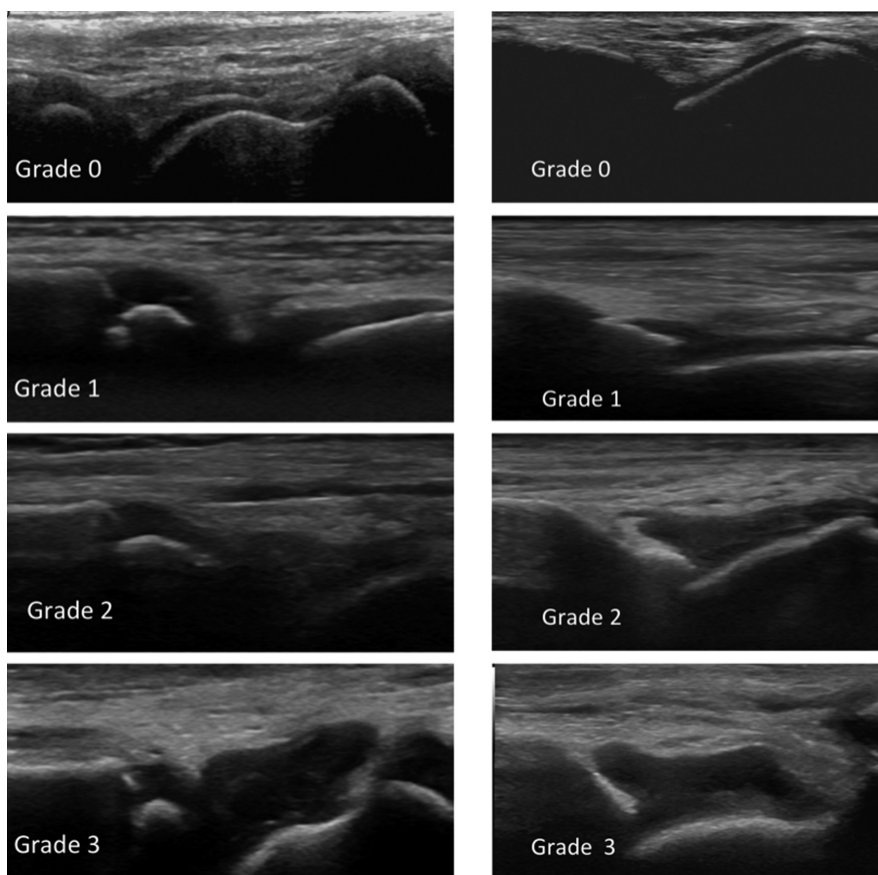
Scoring systems used for assessment of grey-scale synovitis. Longitudinal sonogram of the dorsal tibio-talar joint. Semi-quantitative scoring system for grey-scale synovitis in JIA (in the left side) compared with semi-quantitative scoring system for grey-scale synovitis in adult rheumatoid arthritis (in the right side).
